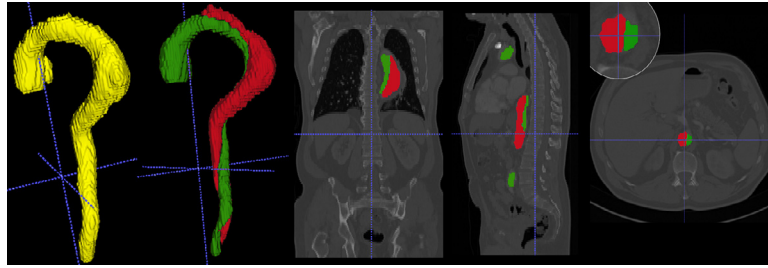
Helical pattern of the false lumen (red) along and around the true lumen (green) of a segmented CTA scan of a patient suffering from an AD. From left to right: whole aorta (yellow), true/false lumen in 3D, true/false lumen in coronal, sagittal and axial views. (For interpretation of the references to colour in this figure legend, the reader is referred to the web version of this article.)
